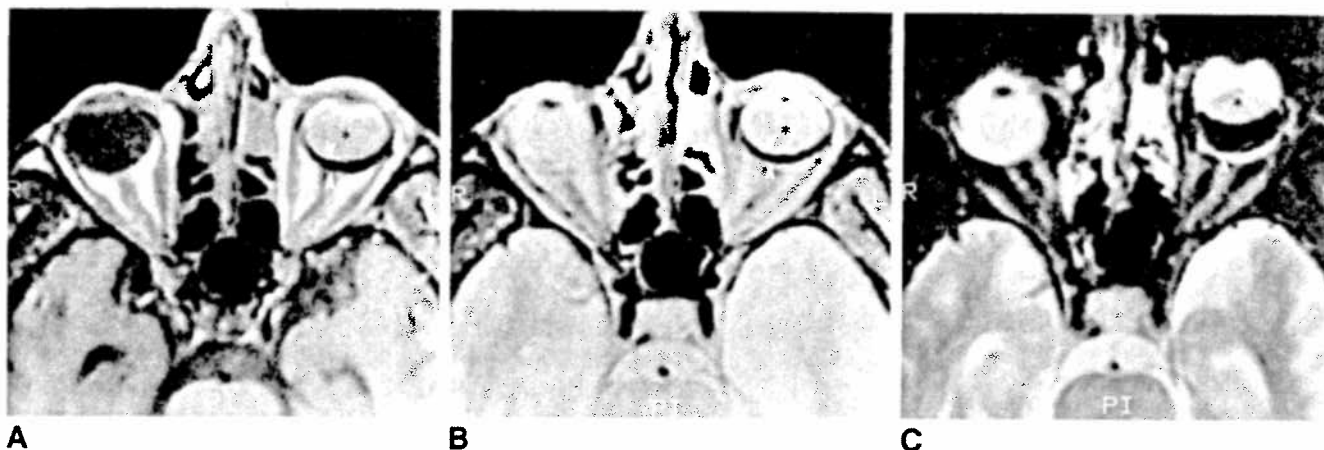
MR study of a patient (case 1) with cytomegalovirus retinitis and a detached retina of the left eye treated with silicone oil injection. Compared with the normal vitreous in the right eye, silicone oil (*asterisk*) is hyperintense on T1-weighted images (A, 500/31), isointense on spin-density-weighted images (B, 3000/31), and hypointense on T2-weighted images (C, 3000/90). Note the chemical shift artifacts (*arrowheads*) on all images, particularly on the T2-weighted image, which was performed with a narrow bandwidth.
